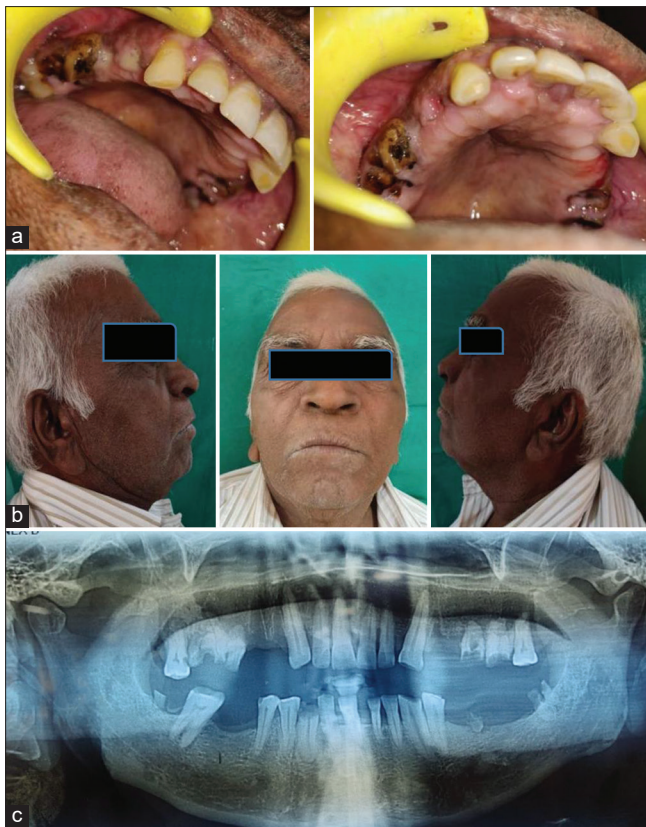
(a) Intraoral pre-operative photographs. (b) Extraoral pre-operative photographs. (c) Pre-operative radiograph
